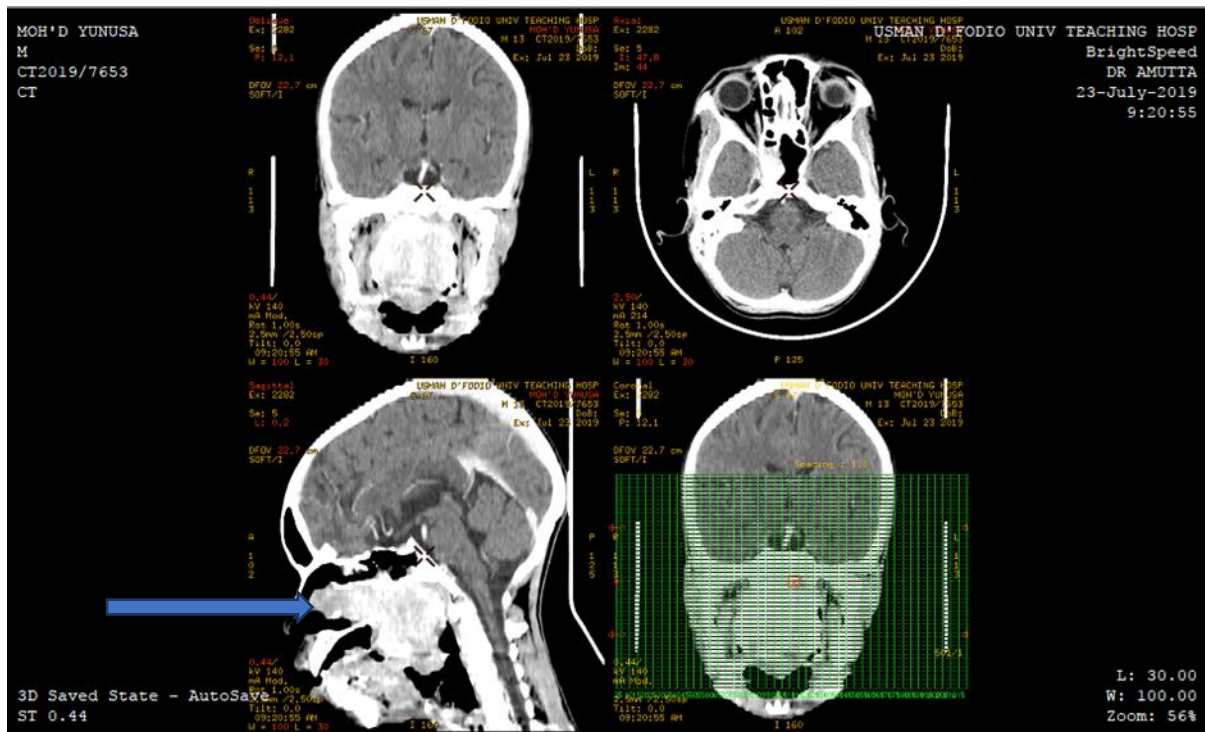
Axial, coronal, and sagittal reconstruction of the CT scan paranasal sinuses showing enhancing mass (blue arrow) in the nasopharynx and nasal cavity.
